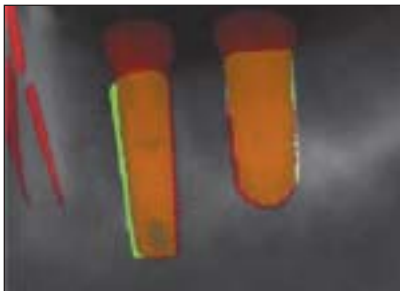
Software presentation of virtual placement of an implant relative to the CT segment used to plant treatment.
